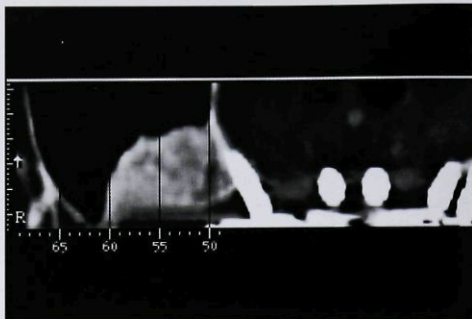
Postoperative CT scan of the patient shown in Fig 1 at 13 months. Sinus floor is displaced apically. A dense, radiopaque matrix into the sinus suggests bone formation.
